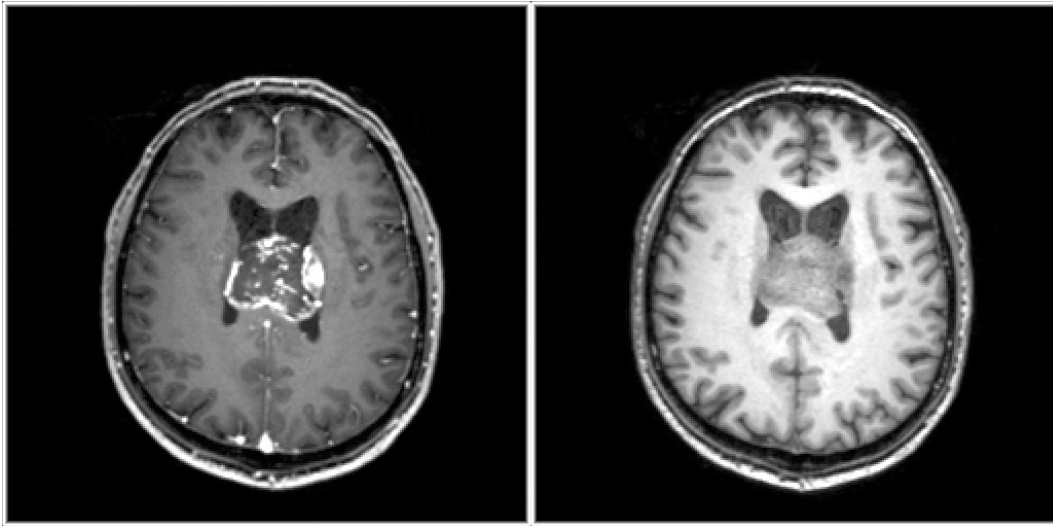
Corresponding slices from two MRI volumes of the same patient. Left, a T1 weighted MRI with contrast fluid used to highlight the tumor, and right, a T1 image acquired without the use of contrast fluid.
